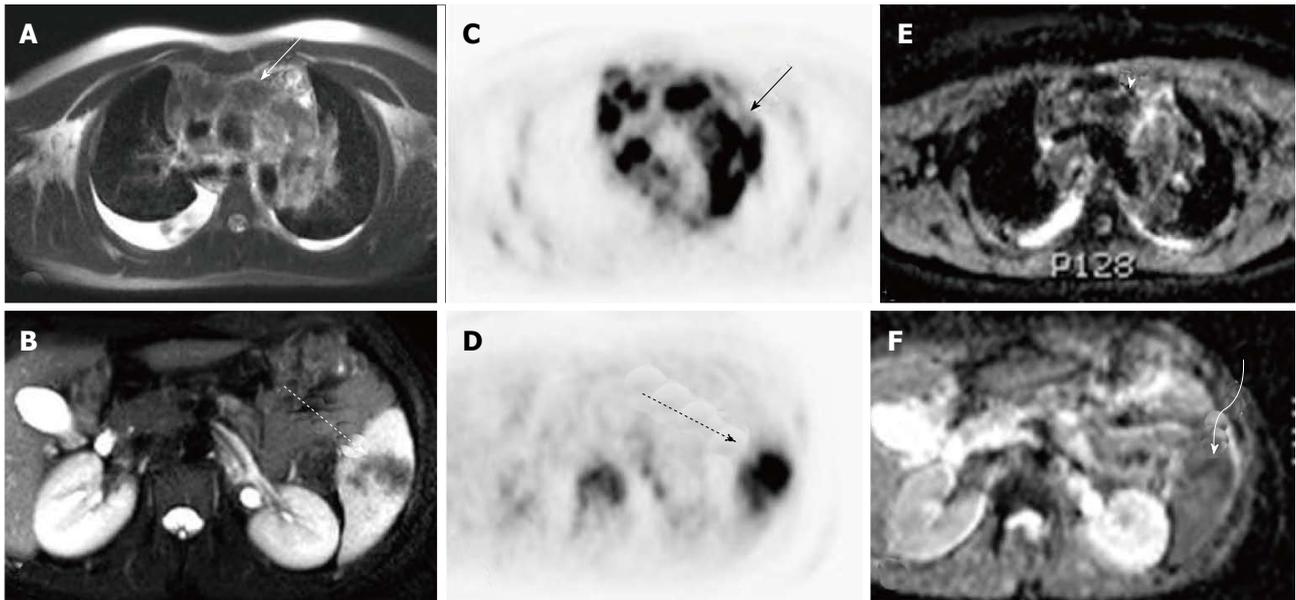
18-year-old male with nodular sclerosing Hodgkin's lymphoma. Axial T2-weighted MRI images of the chest (A) and abdomen (B) demonstrate enlarged mediastinal lymph nodes (white solid arrow) and a region of hypointensity within the spleen (white dashed arrow). Axial images from the concurrently obtained PET examination (C and D) demonstrate intense radiotracer uptake within the mediastinal lymph nodes (solid black arrow) and spleen (dashed black arrow). Axial ADC map images through the same regions (E and F) show areas of decreased signal intensity corresponding to the areas of radiotracer uptake (arrowhead and curve arrow). PET: Positron emission tomography; MRI: Magnetic resonance imaging; ADC: Apparent diffusion coefficient.
